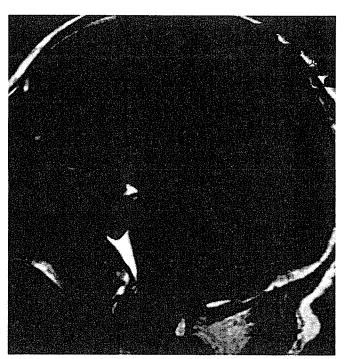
MRI showed cerebellar atrophy without obvious brainstem involvement in Case 1 (table E-1).
